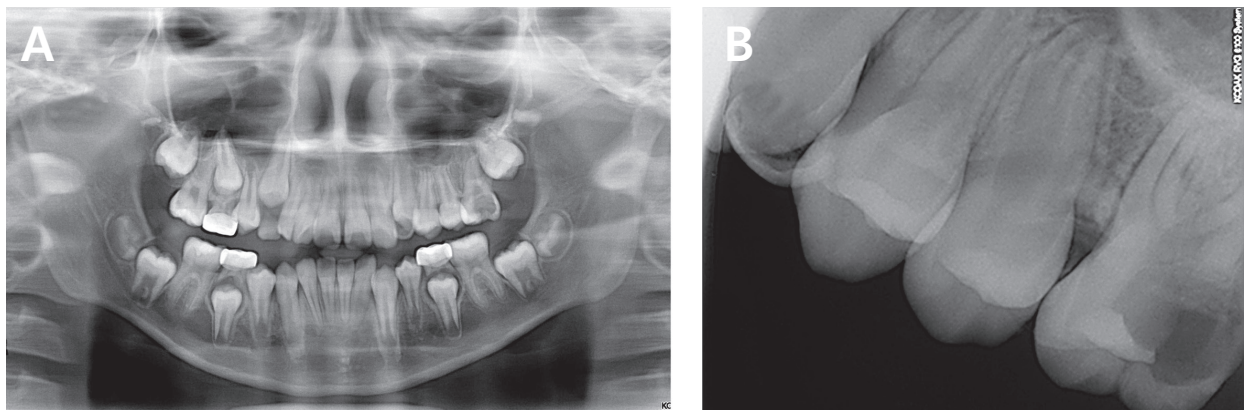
(A) Initial panoramic radiograph of the left maxillary first molar (#26) in a 9-year-old female patient, (B) Periapical radiograph of the tooth, #26, with severe loss of distal coronal tissue.
